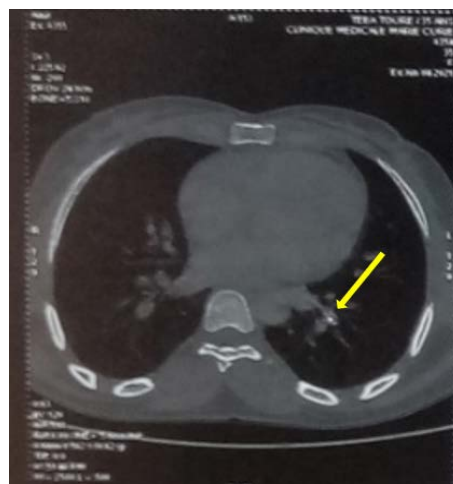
Horizontal cross-sectional chest CT scan showing the implant encapsulated in the left pulmonary artery.
